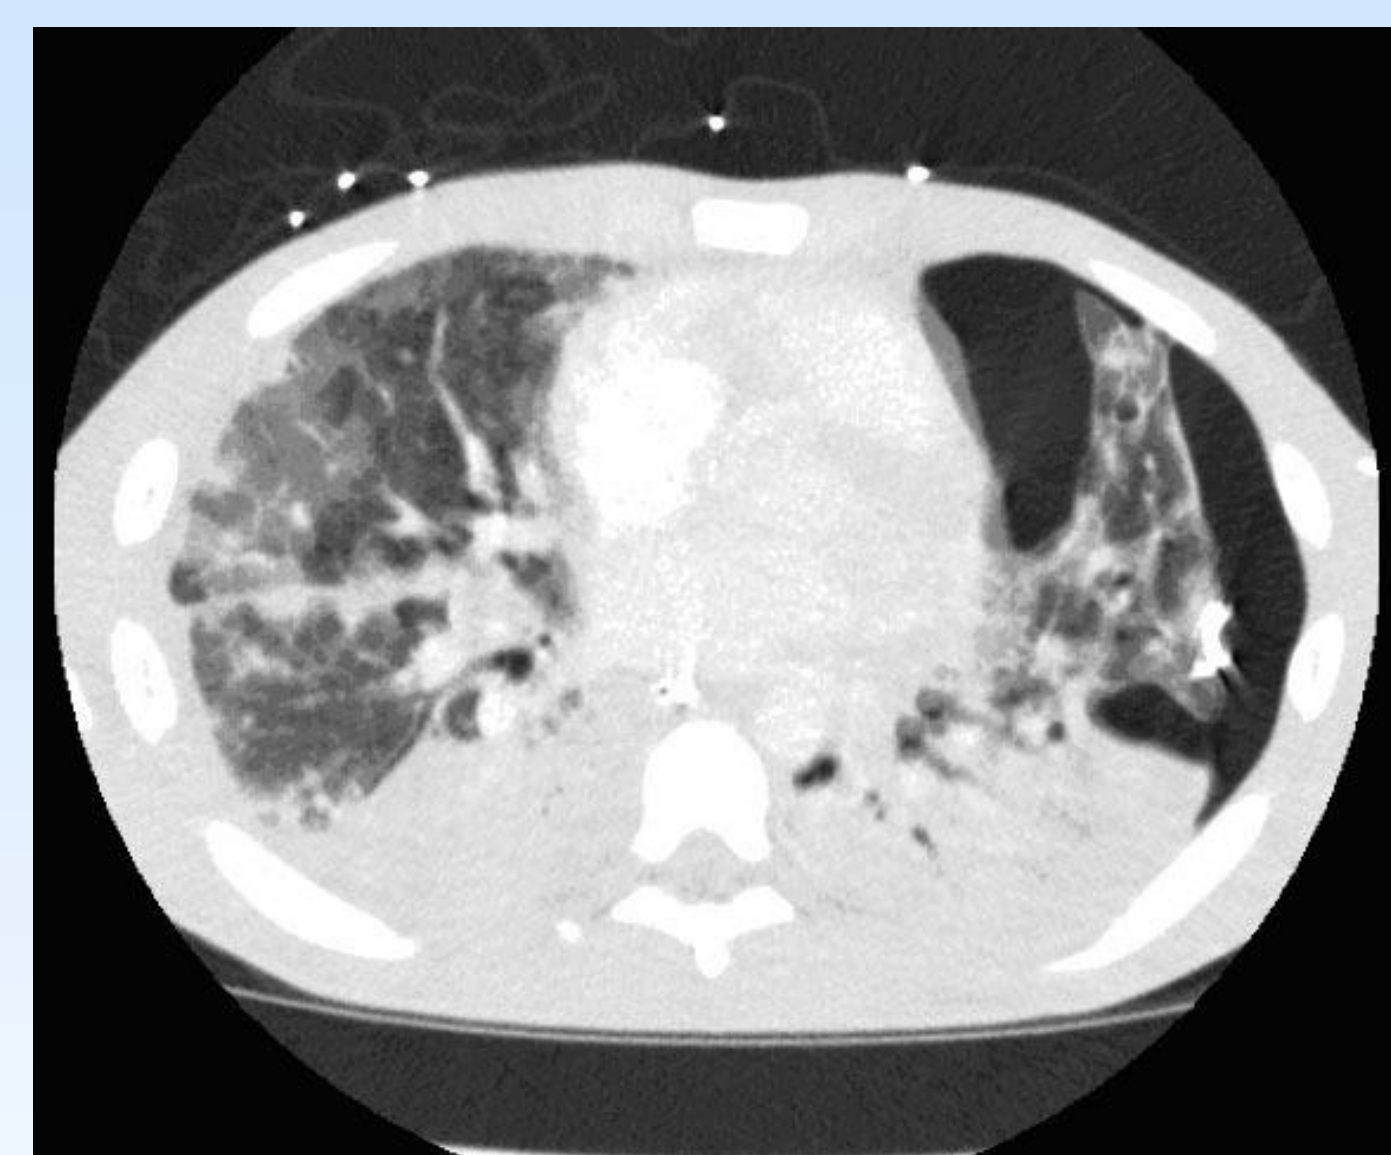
CT chest with IV contrast with extensive lung consolidation bilaterally and left pneumothorax
